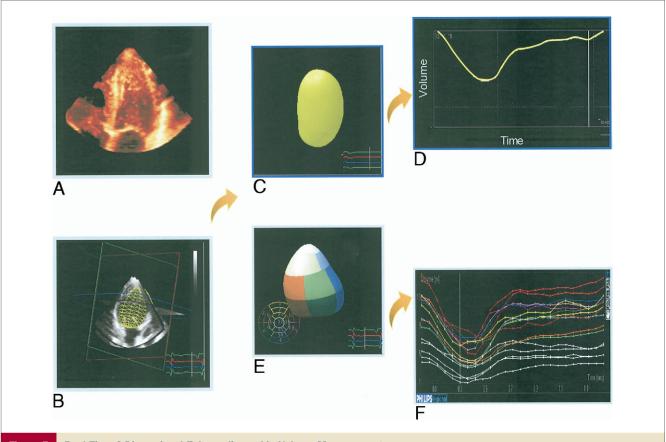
Real Time 3-Dimensional Echocardiographic Volume Measurements
